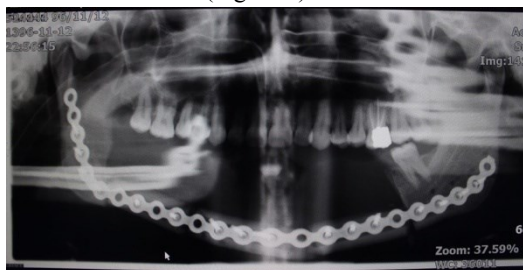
Panoramic radiograph 1.5 months after partial resection of the mandible with bone reconstruction by a titanium plate
